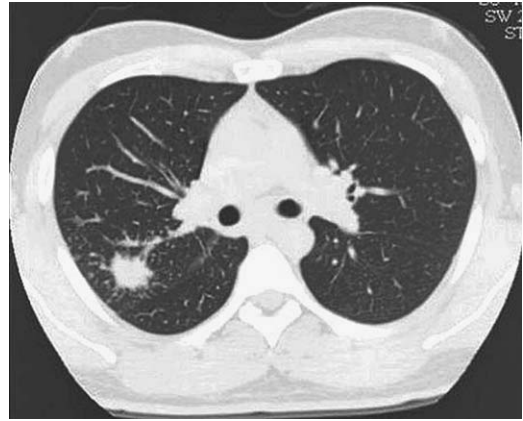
CT scan of acute histoplasmosis demonstrating non-specific nature of the parenchymal opacity.
